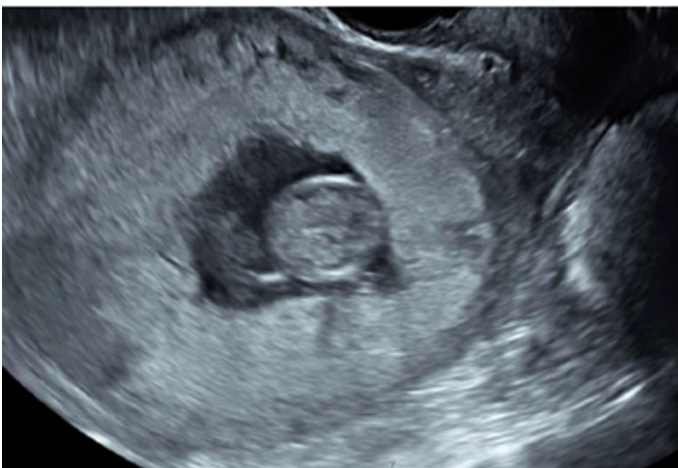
Ultrasound at 11w6d of IVF pregnancy demonstrating small, dilated vessels in anterior myometrium.
